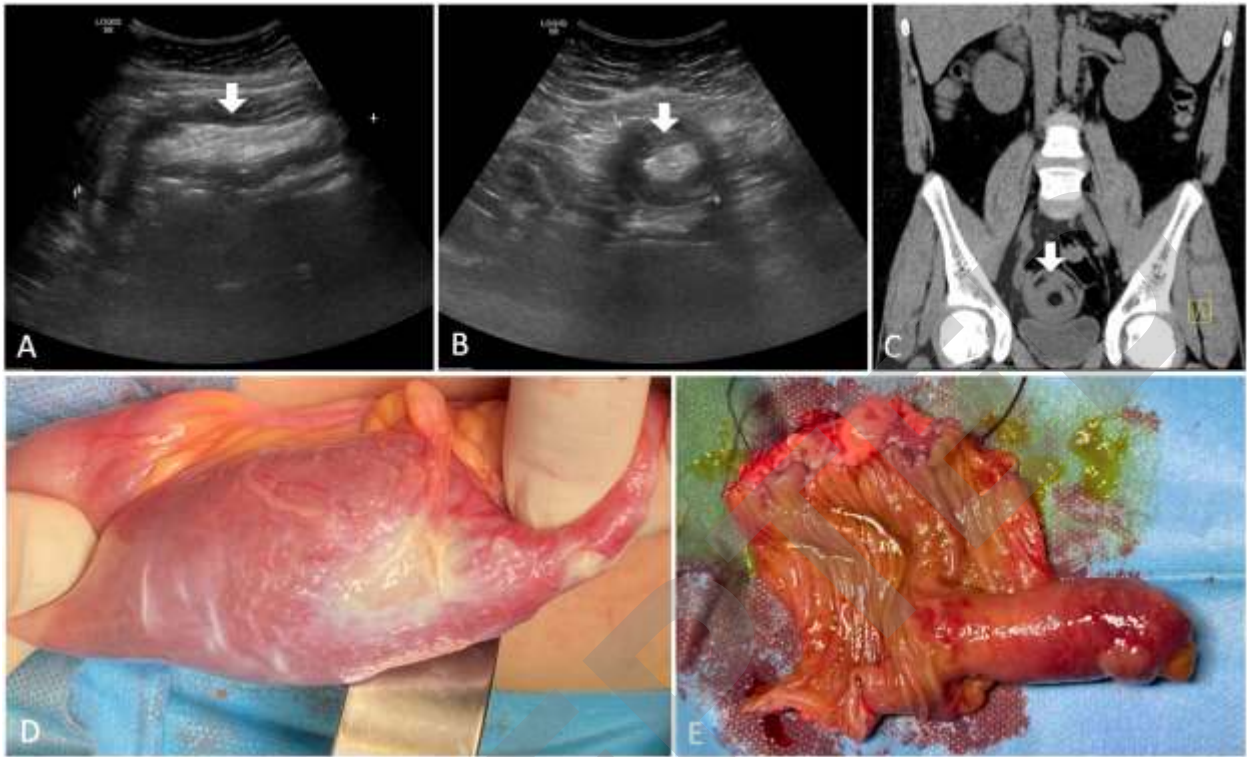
Image of the Month Poll A teenager presents with colicky abdominal pain and an intussusception is noted on imaging - abdominal ultrasonography and computed tomography (see below). A Meckel's diverticulum precipitated intussusception is suspected. Which is the most likely mechanism?
